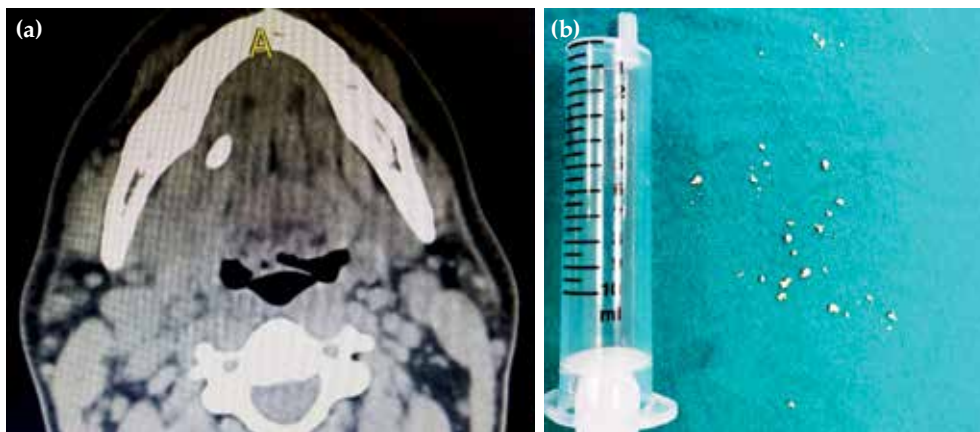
(a) Computed tomography view of the patient with stone in submandibular gland. (b) Stones fragmentation by holmium:yttrium aluminum garnet laser and taken out of the duct by baskets and NGage catheter.
